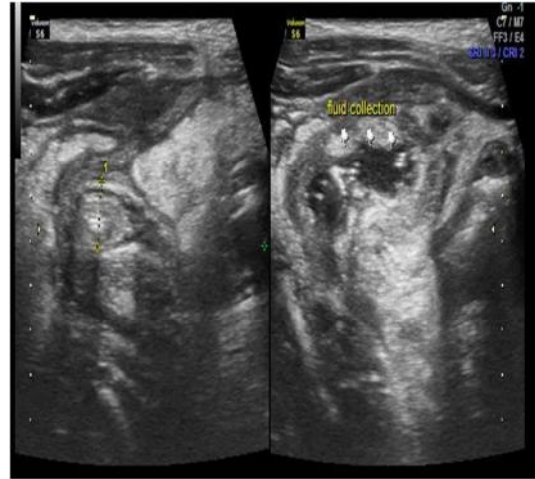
(N,O).Right lower quadrant sonogram of 9 years old male child with perforated appendix & Appendicular Abscess appearing as a debris-filled fluid collection with surrounding echogenic fat.
